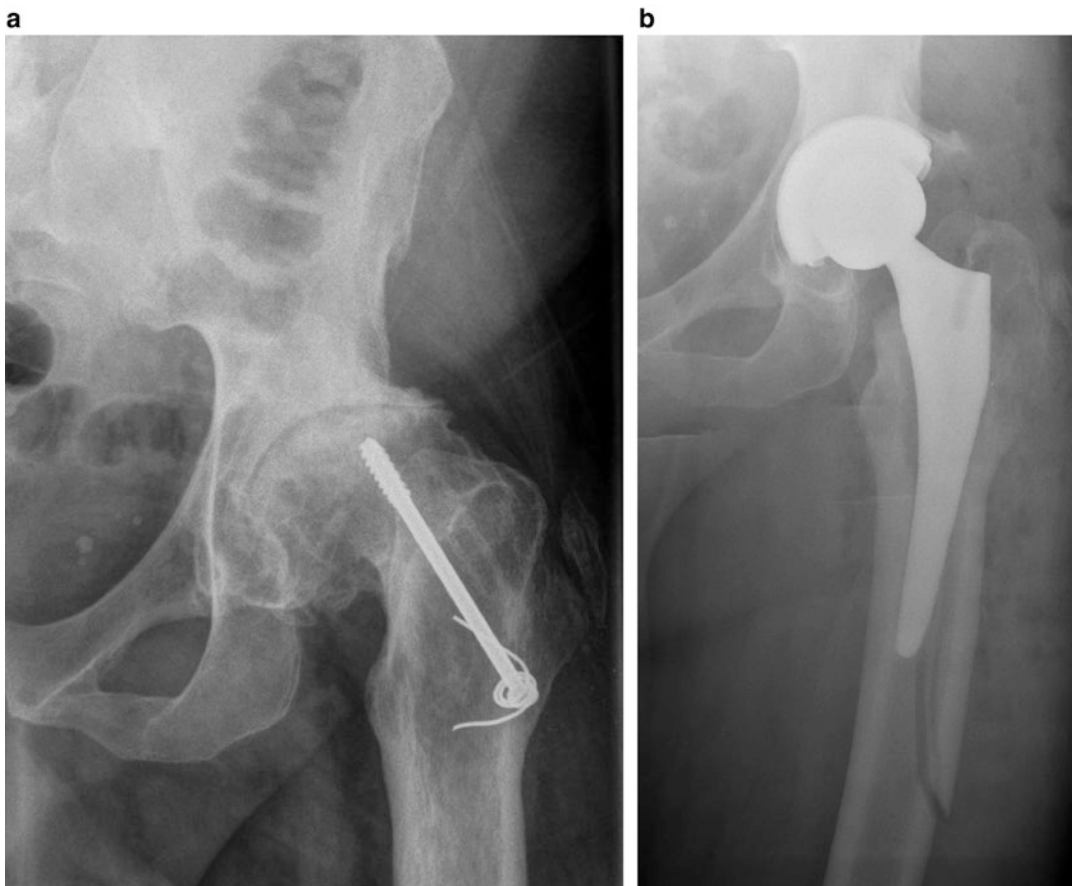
(a) Preoperative radiograph demonstrating hip osteoarthritis following slipped capital femoral epiphysis. (b) Intraoperative femoral fracture in the diaphyseal region discovered postoperatively
